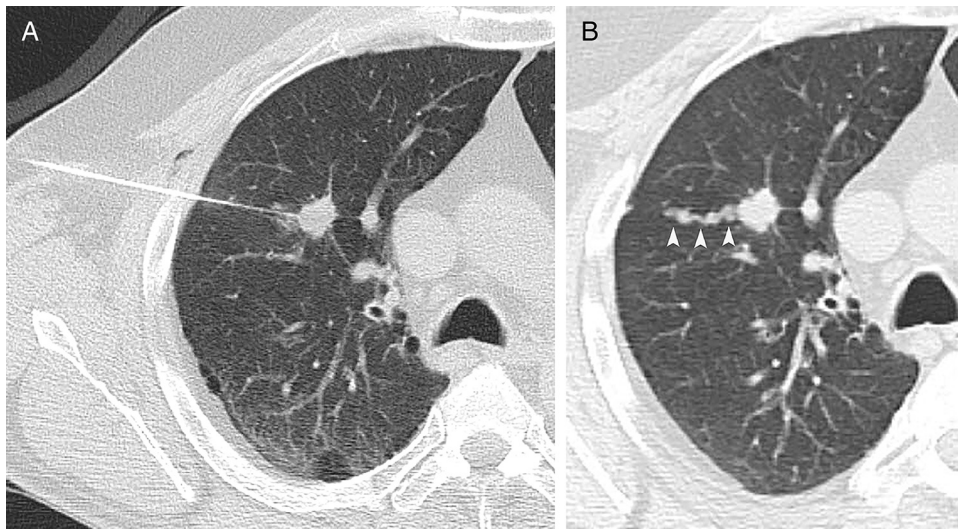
A 70-year-old man with non-small cell lung cancer who had a computed tomography (CT)-guided transthoracic biopsy and injection of a hydrogel plug to prevent pneumothorax. (A) Axial CT image shows the biopsy needle path; (B) Axial CT image 3 months after (A) shows a serpiginous tract within the lung parenchyma along the path of the biopsy needle (arrowheads). The tract remained unchanged on follow-up imaging 12 months later (not shown).
